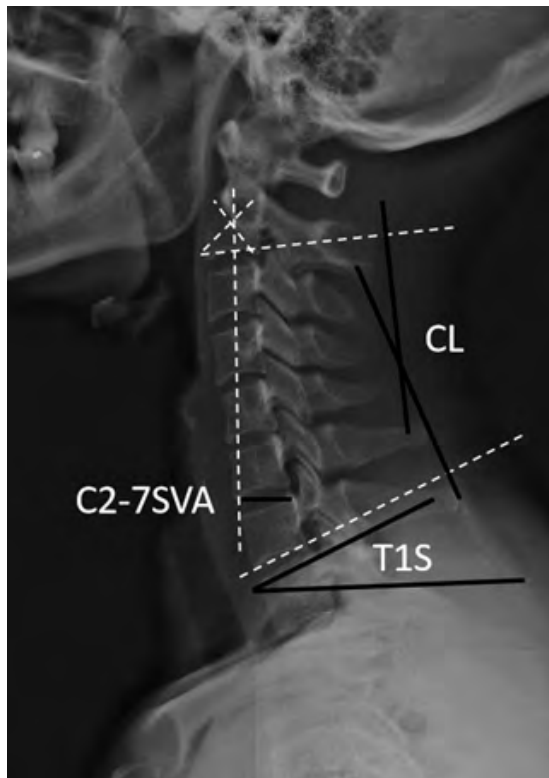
Measurements of parameters, including T1 slope, cervical lordosis, and C2-7 SVA on lateral X-ray radiographs.
